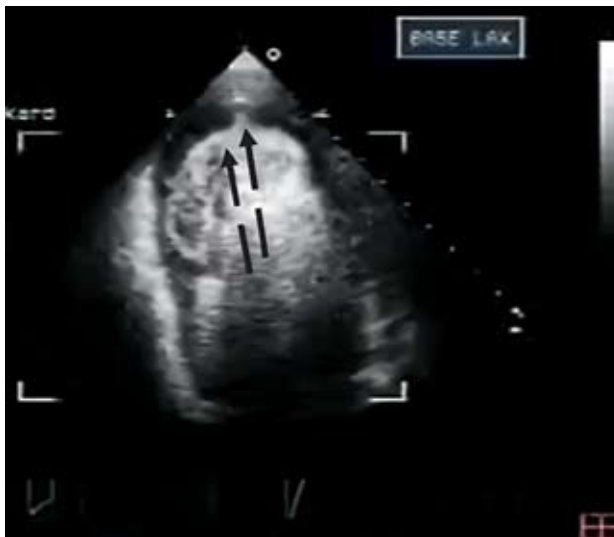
Myocardial contrast echocardiography images in the apical four-chamber view. The arrows show the contrast extrusion from the left ventricular cavity into the myocardium in the apex, suggesting a dissecting intramyocardial haematoma.
